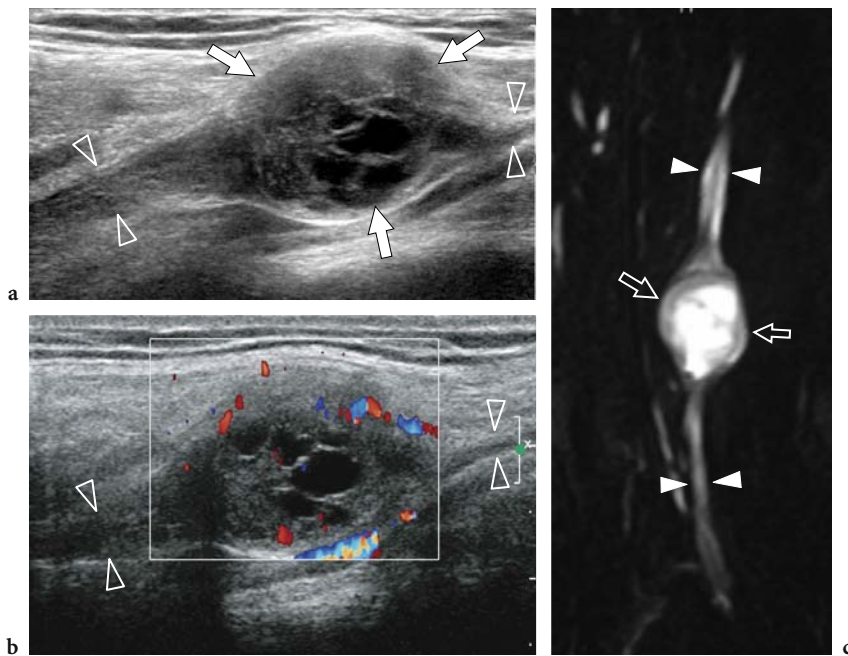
Cystic schwannoma. a,b Long-axis a gray-scale and b color Doppler 12–5 MHz US images over the radial nerve (*arrowheads*) at the arm with c MR-neurographic correlation show a rounded mass (*arrows*) with intratumoral cystic changes, related to accumulation of myxoid matrix, in continuity with the parent nerve (*arrowheads*). The tumor exhibits a hypervascular pattern made up of peripheral and central color Doppler signals
